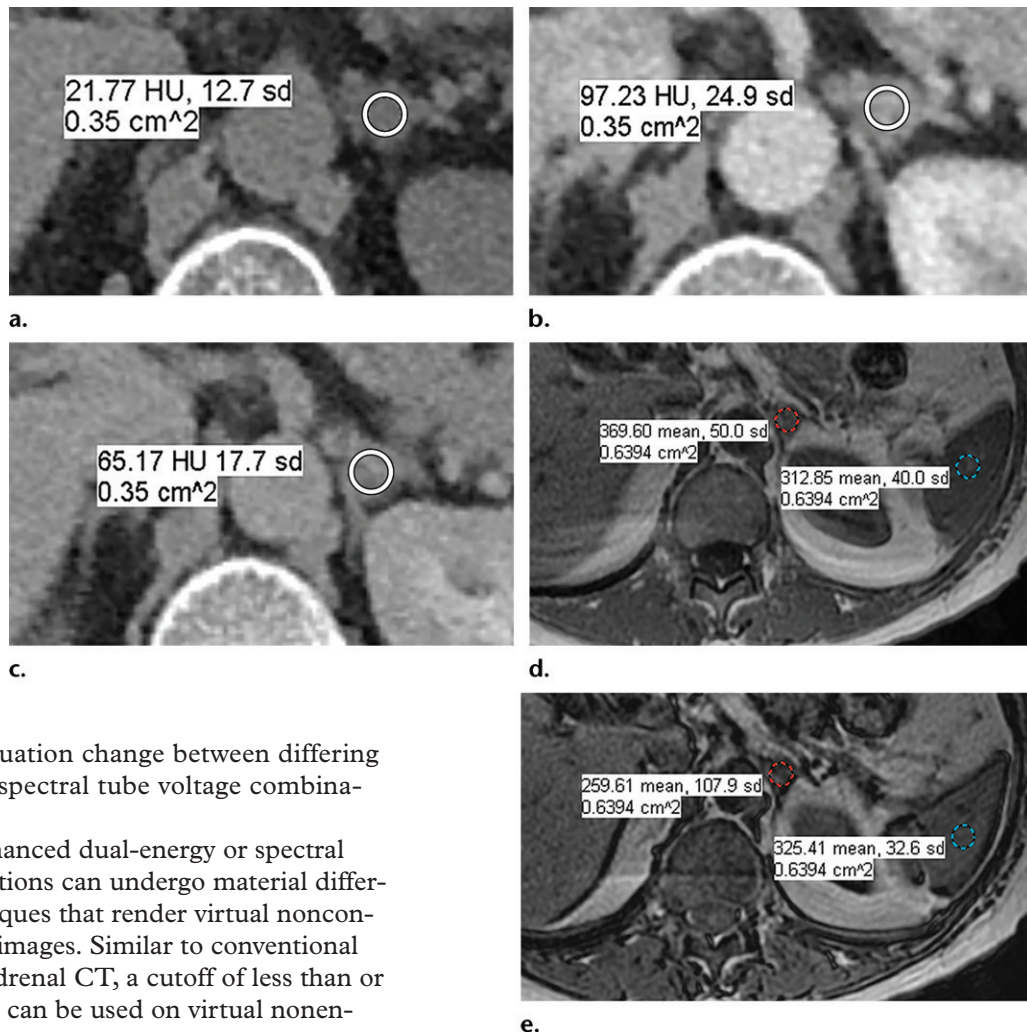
(a–c) Axial precontrast (a), portal venous phase (b), and 15-minute delayed phase (c) adrenal washout CT images obtained by using an erroneous tube voltage show an indeterminate left adrenal nodule (absolute washout = 43%, relative washout = 33%, with $>60\%$ absolute or $>40\%$ relative washout being suggestive of an adenoma). Owing to the automatic tube voltage selection, the tube voltage used was 100 kVp, which produced inappropriate measurements of attenuation on the washout examination. These studies should be performed at 120 kVp. (d, e) Axial in-phase (d) and out-of-phase (e) chemical shift MR images show loss of signal within the adrenal lesion, with an adrenal-to-spleen signal intensity ratio of 0.68 (<0.71 indicative of a lipid-rich adenoma), confirming a lipid-rich adenoma. Red dashed circle = ROI selected on the adrenal lesion, blue dashed circle = ROI selected on the spleen.
